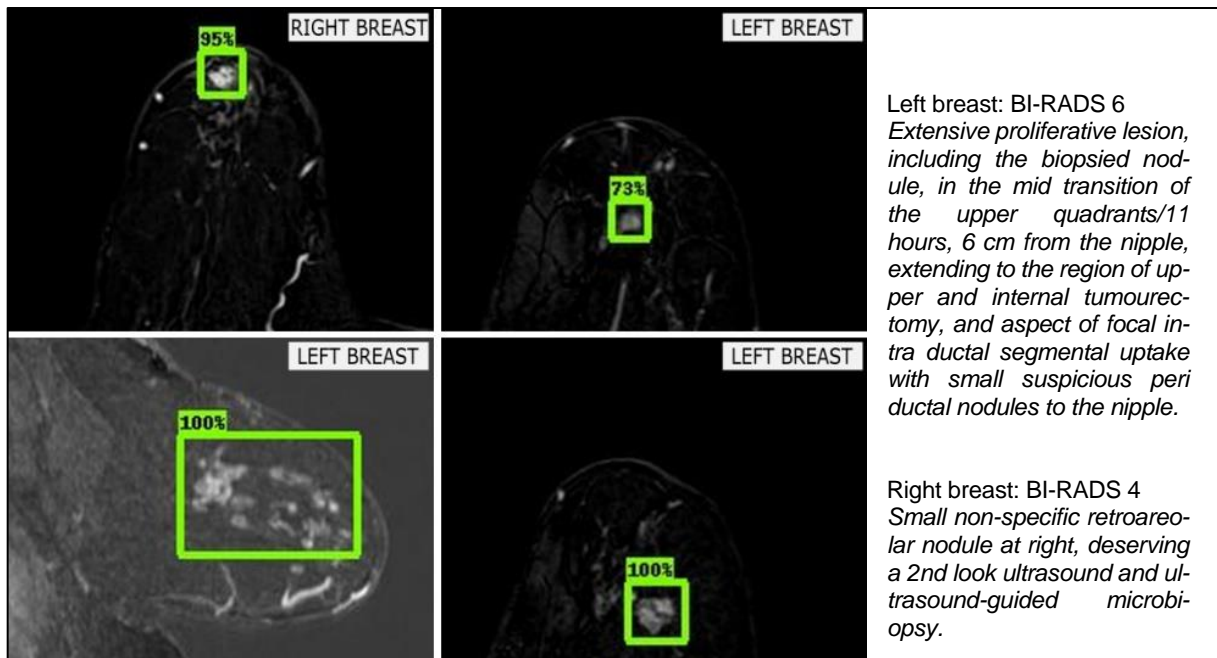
Patient 1 MRI Scan conclusion and image with model B detection depicting the findings.
